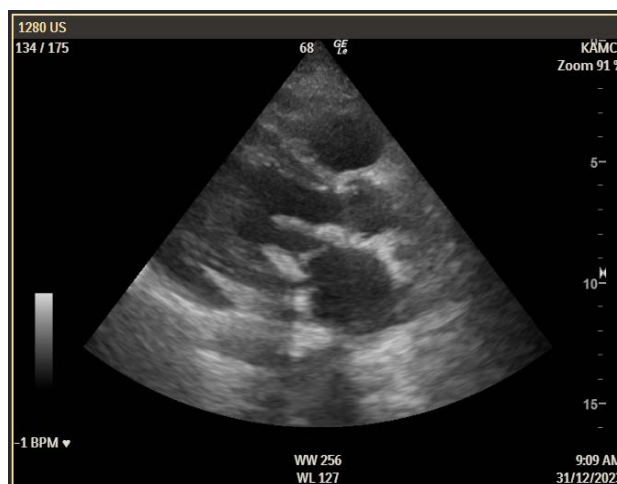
Transthoracic Echo postoperatively showing the new tissue mitral valve.
